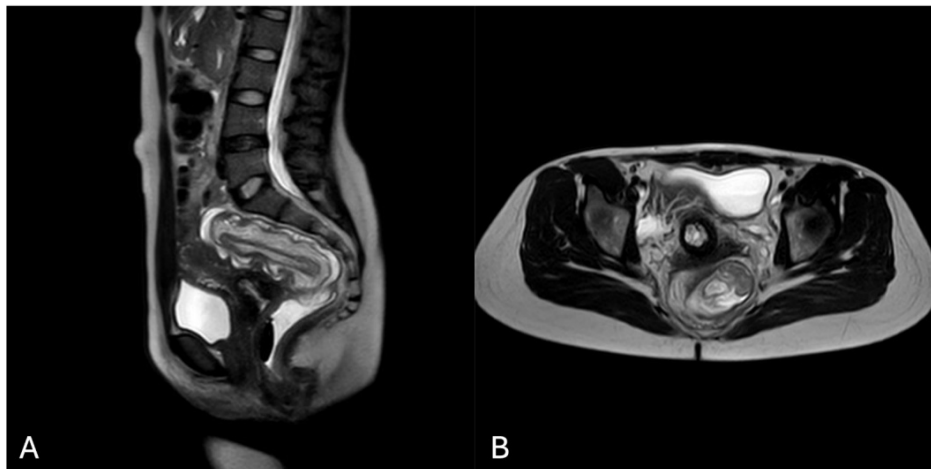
MRI T2-weighted images. A. Sagittal section showing colorectal invagination. B. Axial section showing the villous adenoma.
